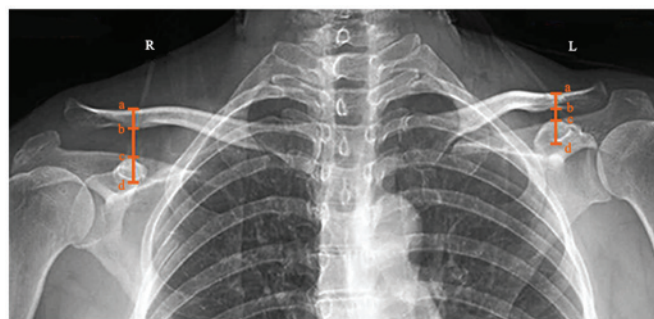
Preoperative radiographs of shoulders of injured side (right) and uninjured side (left). The CC-interval was vertical distance of the upper edge of clavicle to lower edge of coronoid, was measured from a to d, the interval from b to c increased in the injured side.
